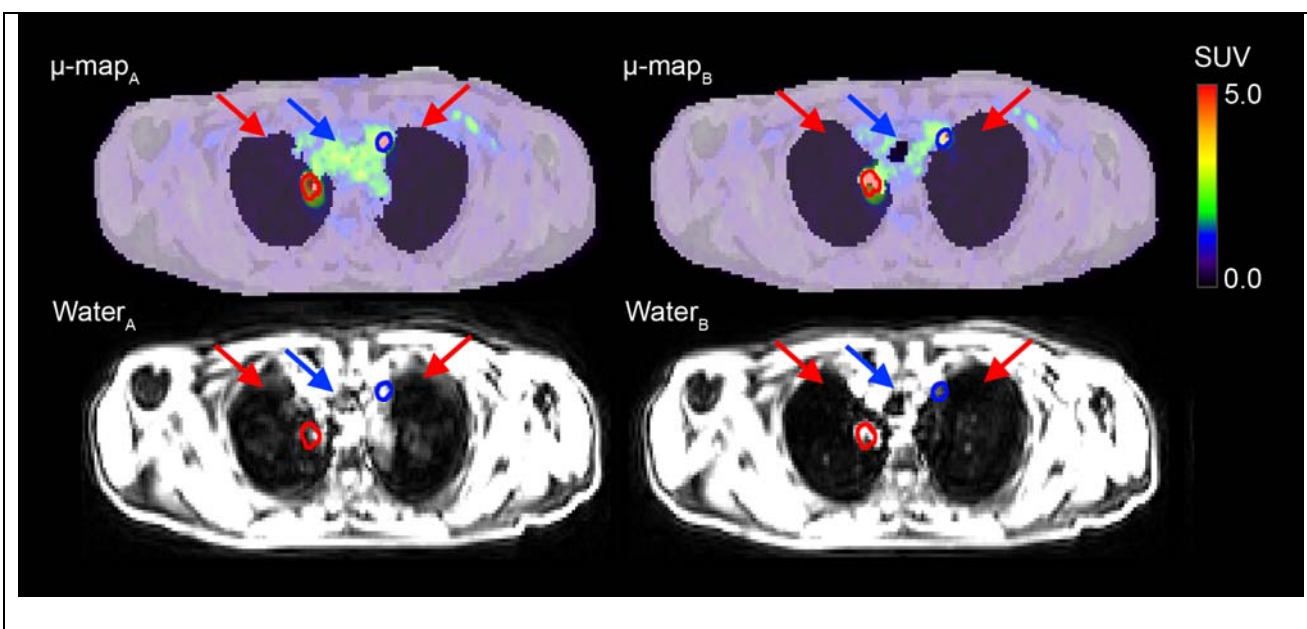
Patient 9, examination 4. Intra-subject repeated MR-AC maps ( $\mu\text{-map}_A$  and  $\mu\text{-map}_B$ ) fused with  $\text{PET}_A$  and  $\text{PET}_B$ , along with their respective Dixon water images. Respiratory motion causes incorrect tissue classification in  $\mu\text{-map}_A$ . The trachea is completely missed (blue arrows) and an incorrect classification of lung tissue as soft tissue can be seen (red arrows). As a result  $\text{PET}_B$  is lower relative to  $\text{PET}_A$  for the tumor delineated in blue ( $\Delta\%SUV_{\max}$  of -21%) as  $\text{PET}_A$  is locally overcorrected for attenuation (SUV values too high). The tumor delineated in red is in  $\mu\text{-map}_A$  incorrectly classified as lung tissue, which causes undercorrection for attenuation in  $\text{PET}_A$  and causes  $\text{PET}_B$  to be slightly higher relative to  $\text{PET}_A$  ( $\Delta\%SUV_{\max}$  of 5%).
